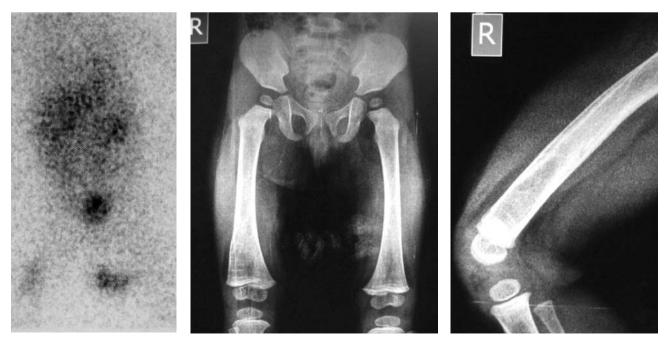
Pathological involvements in MIBG scintigraphy
